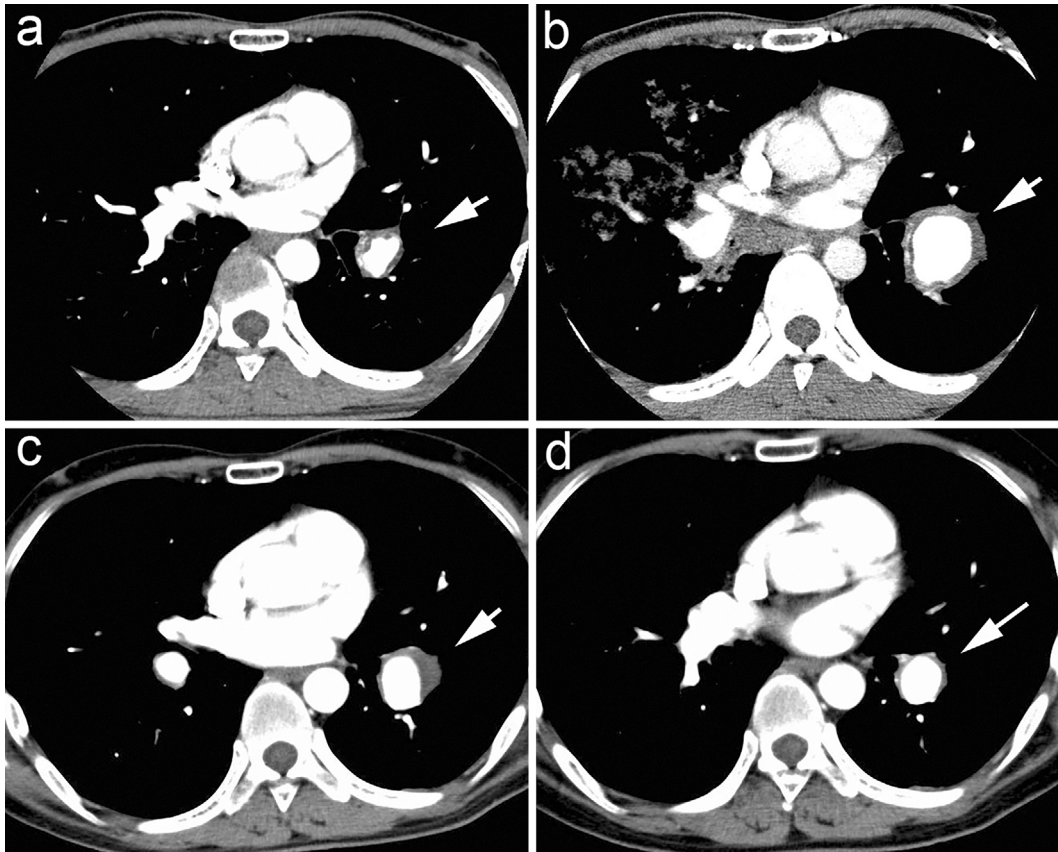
Chest CT at first admission (a), second admission (b), three months after the second admission (c), and five months after the second admission (d). The arrows indicate the left pulmonary artery.
